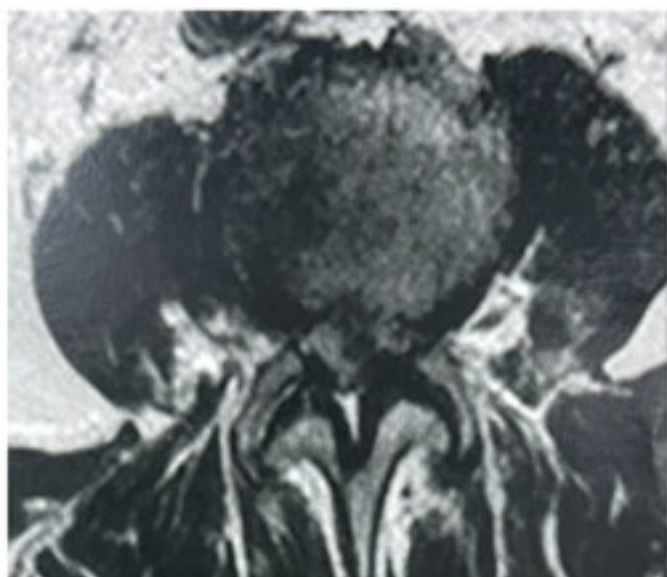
T2-weighted magnetic resonance imaging of the lumbosacral spine, axial section at the level of the L3-L4 foramen, demonstrating left median and paramedian herniation, with stenosis of the corresponding neuroforamen.
